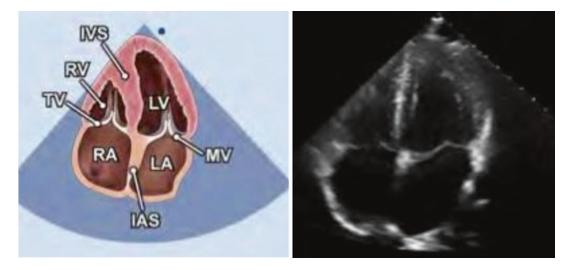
Apical four-chamber view. (Reprinted from Mitchell et al. [11]. With permission from Elsevier)
